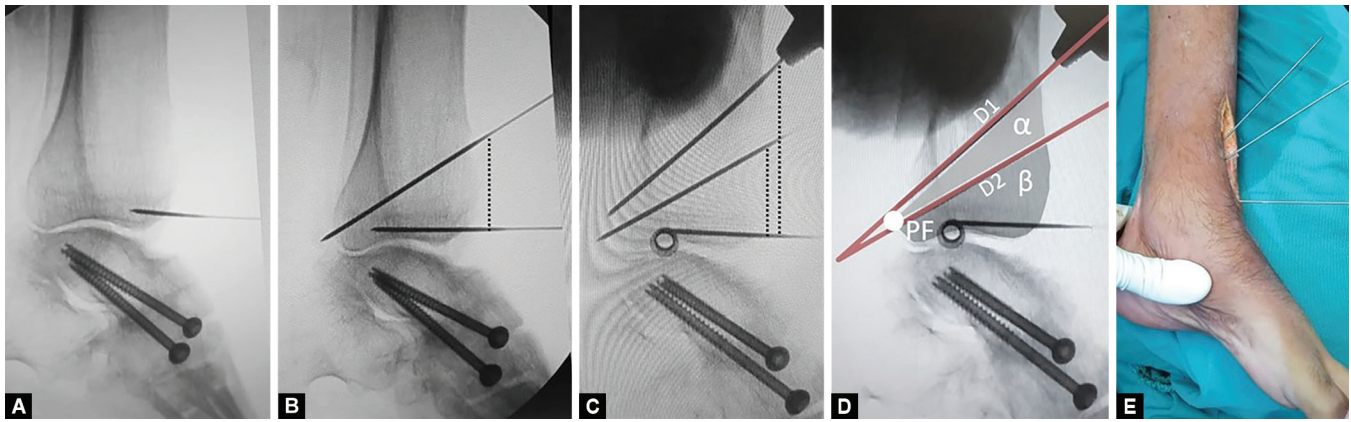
Measurement of the distances between the joint line (0 cm) and the point of entrance of the K-wires that will guide the proximal and distal cuts (distances depicted in this radiograph are examples)
